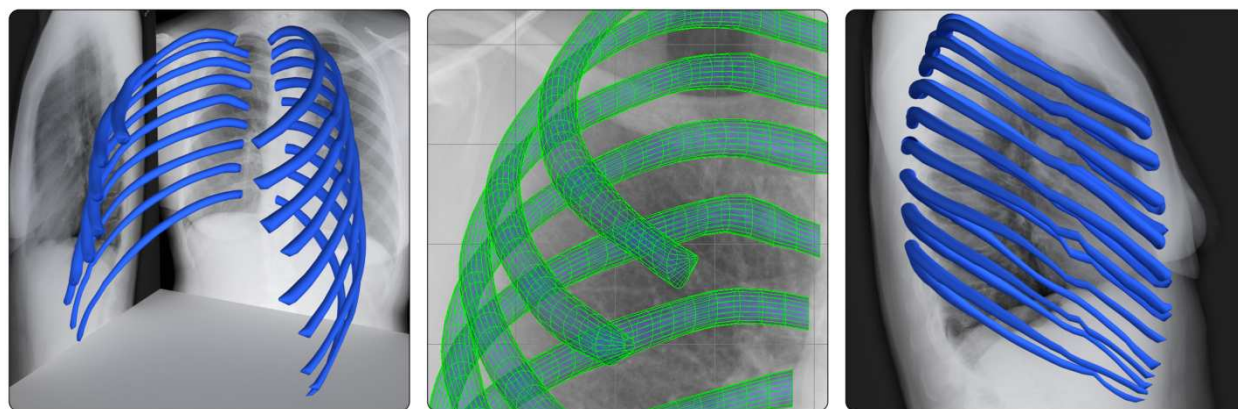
Fitting the deformed template to the lateral X-ray image.
